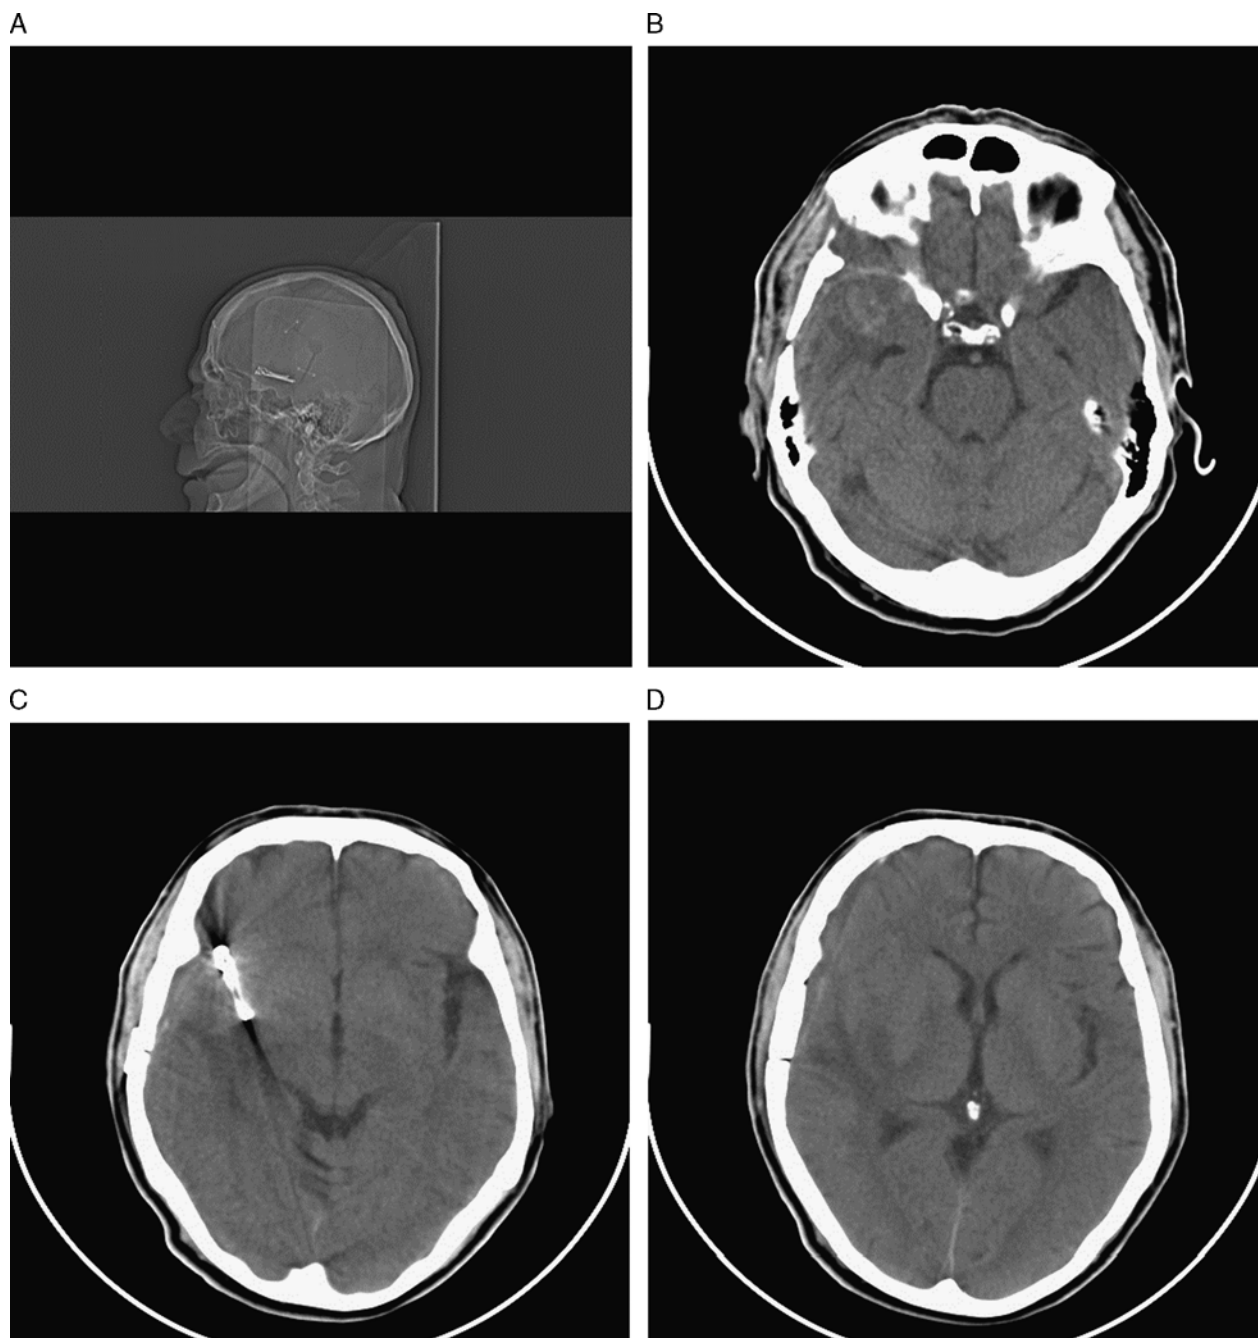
Patient J.A.'s computed tomogram of the head on postsurgical Day 18. Panel A: Localizer image. Panels B–D: Axial images in sequential order from inferior (B) to superior (D) show clipping of the aneurysm in his right middle cerebral artery.
